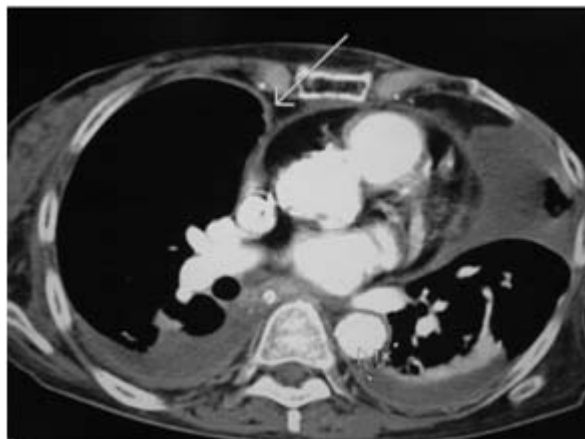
A 66-year-old woman with diffuse large B-cell lymphoma, contrast-enhanced CT scan shows right mediastinal pleural thickening (arrow) and bilateral parietal pleural thickening. Bilateral pleural effusions, loculated on the left, are also noted.
